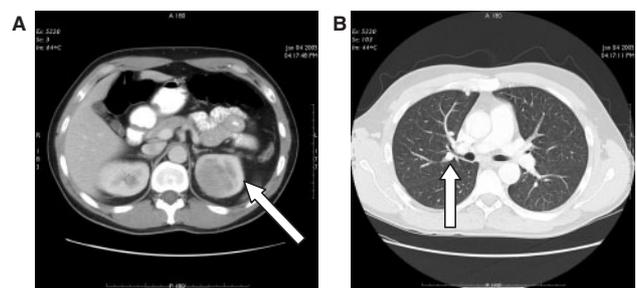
Initial CT showing the renal mass and pulmonary nodule (marked with arrows).
